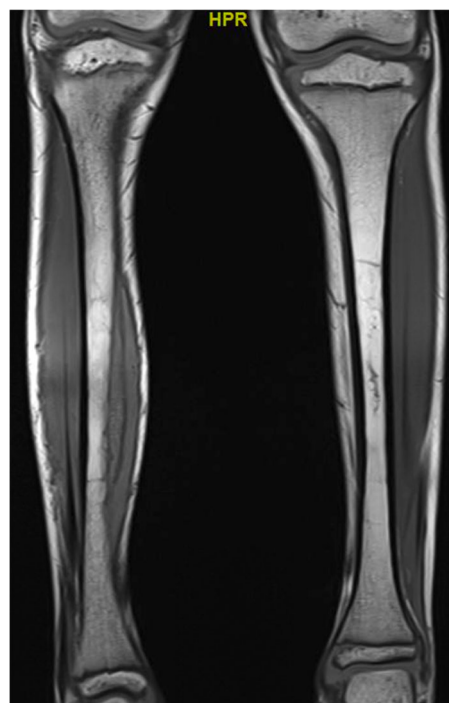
T1 weighted, coronal MRI image without contrast of bilateral legs
